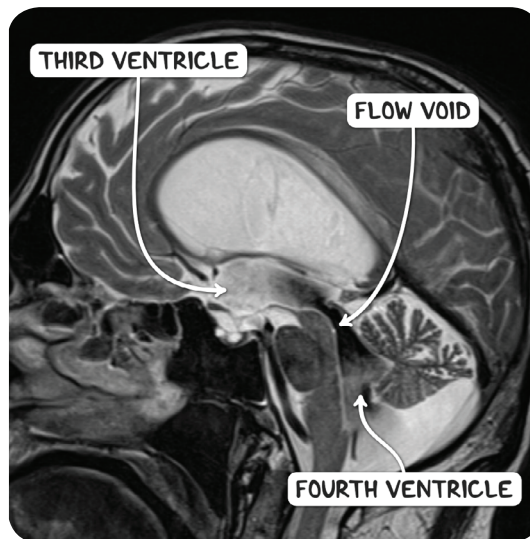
An MRI scan of the head in the sagittal plane demonstrating hydrocephalus. There is a prominent flow void in the sylvian aqueduct, suggesting a normal-pressure hydrocephalus.
